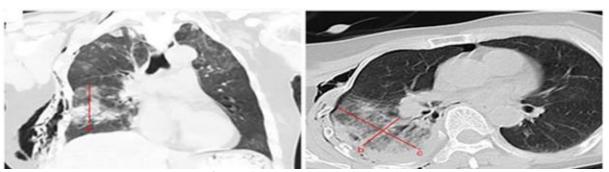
Measurement of PC volume in CT chest.
